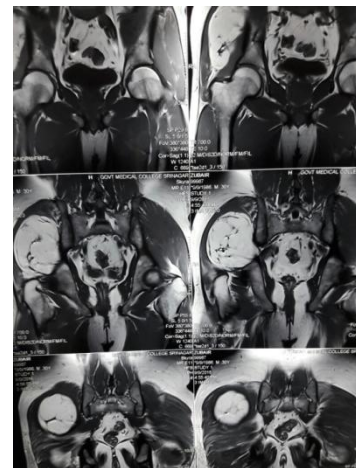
MRI showing the lipoma
